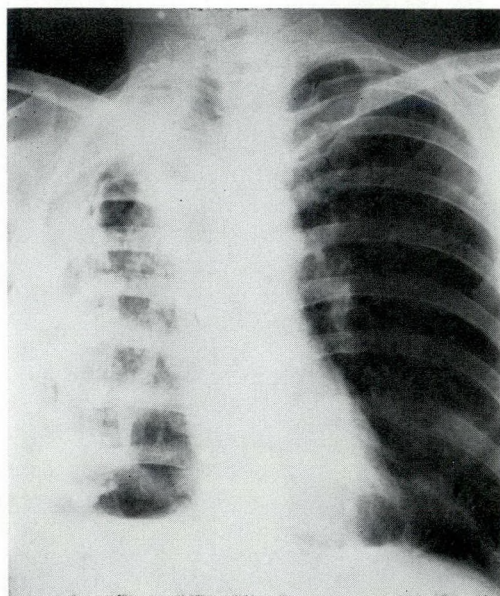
C.B. Chest radiograph January 8, 1968. The right lung has been largely destroyed by tuberculosis. There is a calcified empyema and a bronchopleural fistula.
